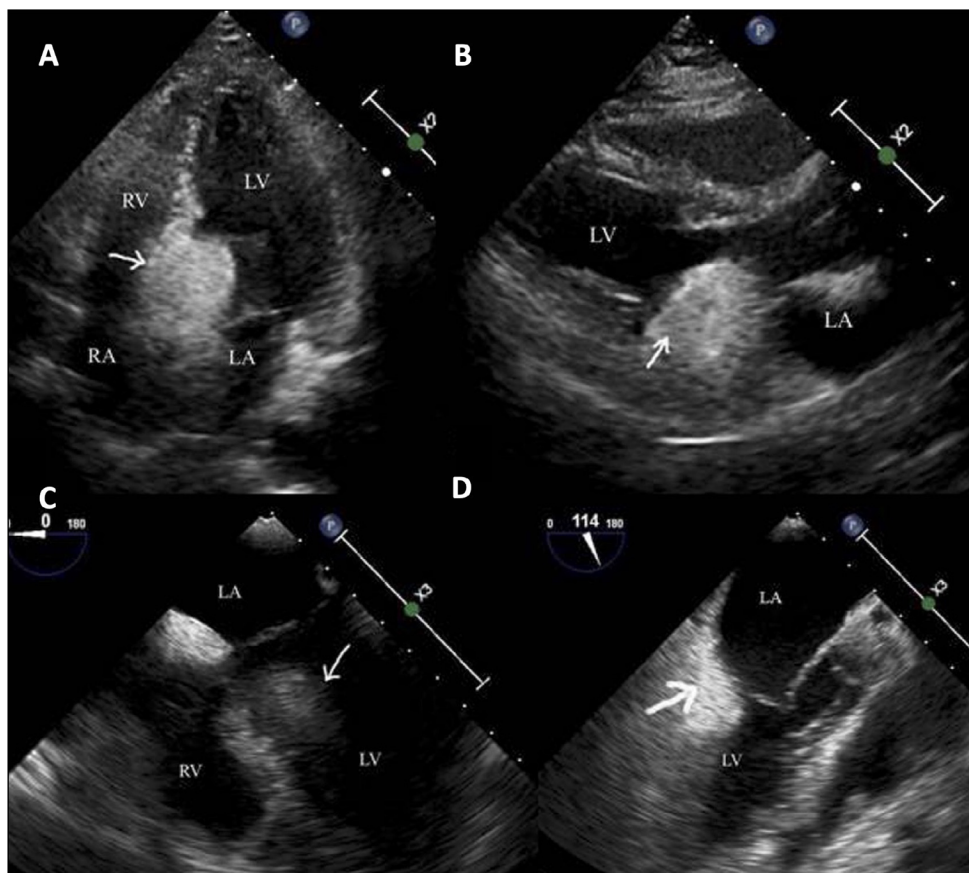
(A) Transthoracic echocardiogram in apical four-chamber view and (B) parasternal long-axis view showing a large echogenic mass in the region of the basal interventricular septum (depicted by white arrow) transesophageal echocardiogram in (C) four-chamber and (D) three-chamber views demonstrate the echodense mass. RV: right ventricle; LV: left ventricle; RA: right atrial; LA: left atrial
